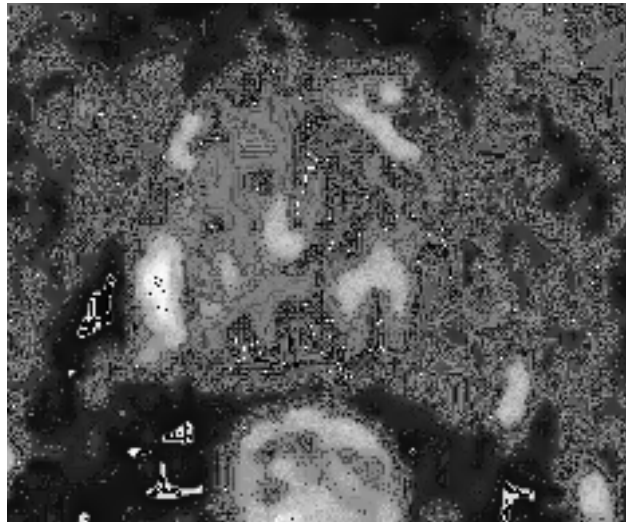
a DWI & 7.b ADC : Focal markedly hypointense area on ADC and hyperintense area on DWI sequence approximately measuring 1.2 cm noted in the peripheral zone on left side categorized PIRADS IV in the peripheral zone.
